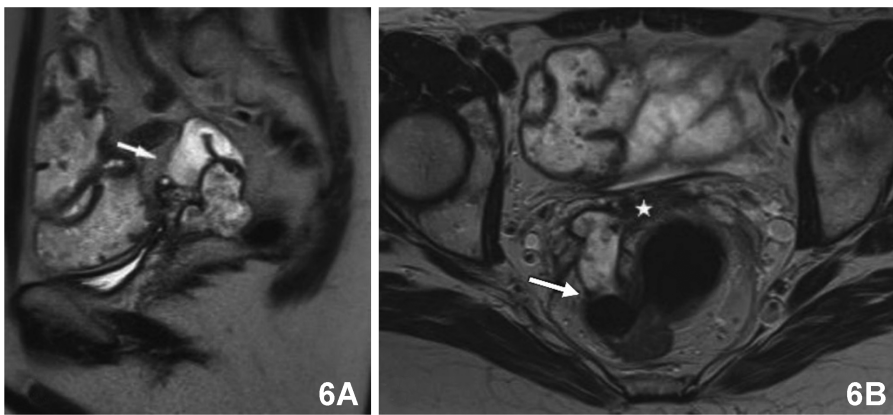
MRI of appendiceal mucinous adenocarcinoma invading the vagina and rectum<sup>[12]</sup>
